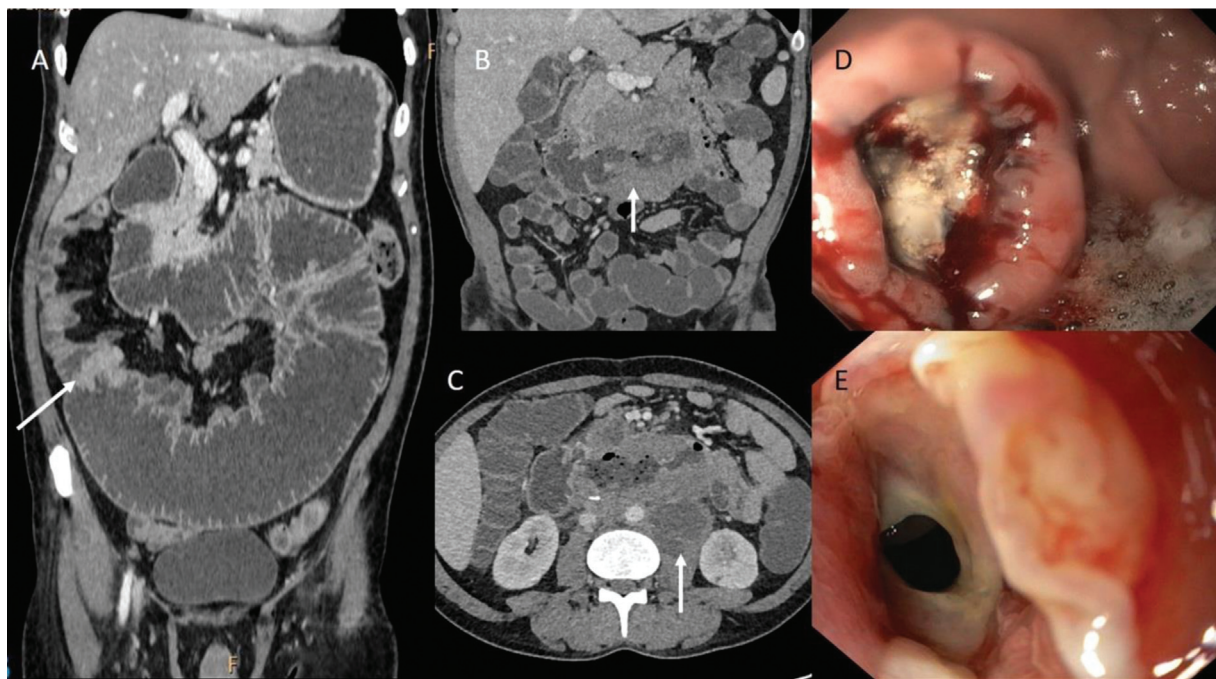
Adenocarcinoma: (A) Coronal computed tomography (CT) enterography image showing asymmetric enhancing mural thickening (arrow) involving distal jejunum causing intestinal obstruction; (B, C): Coronal and axial CT enterography image showing asymmetric mural thickening involving the duodenum with adjacent invasion (arrow in B) and necrotic retroperitoneal lymph nodes (arrow in C); (D, E): Enteroscopic images showing intraluminal polypoidal (D) and annular growth patterns (E).
